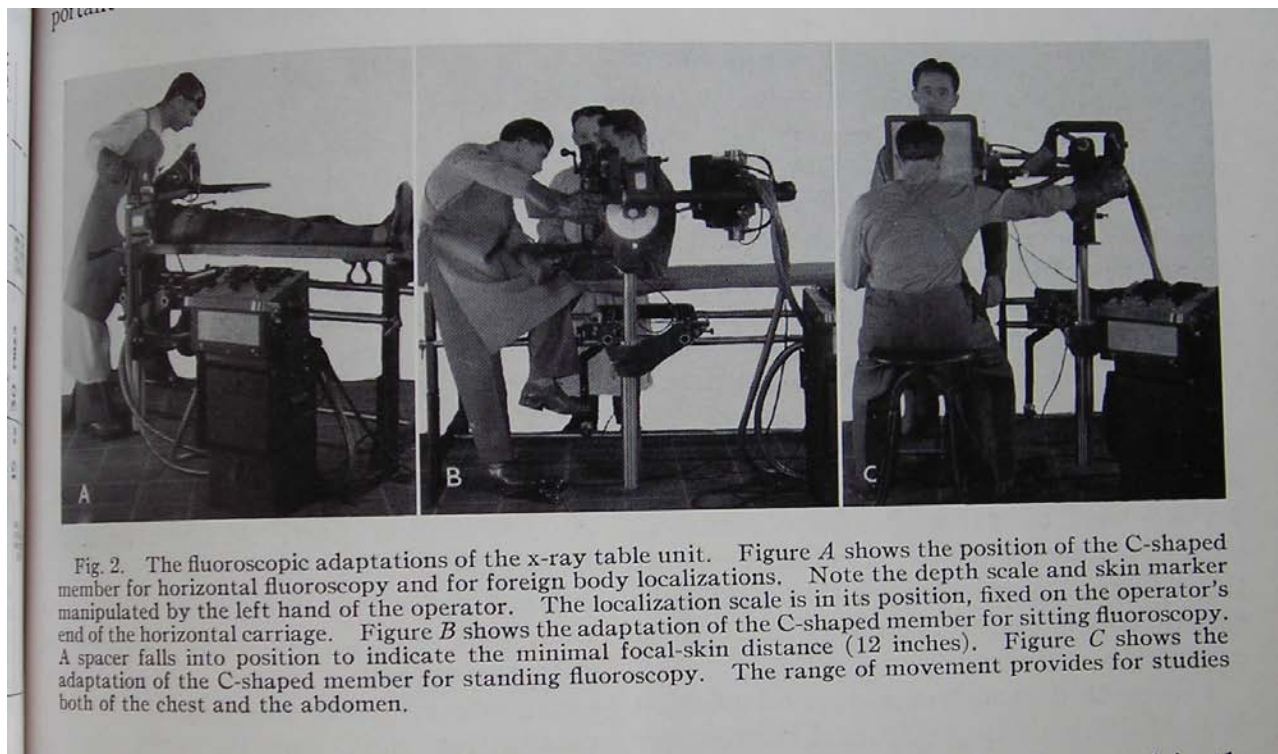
The fluoroscopic adaptations of the x-ray table unit. Figure A shows the position of the C-shaped member for horizontal fluoroscopy and for foreign body localizations. Note the depth scale and skin marker manipulated by the left hand of the operator. The localization scale is in its position, fixed on the operator's end of the horizontal carriage. Figure B shows the adaptation of the C-shaped member for sitting fluoroscopy. A spacer falls into position to indicate the minimal focal-skin distance (12 inches). Figure C shows the adaptation of the C-shaped member for standing fluoroscopy. The range of movement provides for studies both of the chest and the abdomen.
